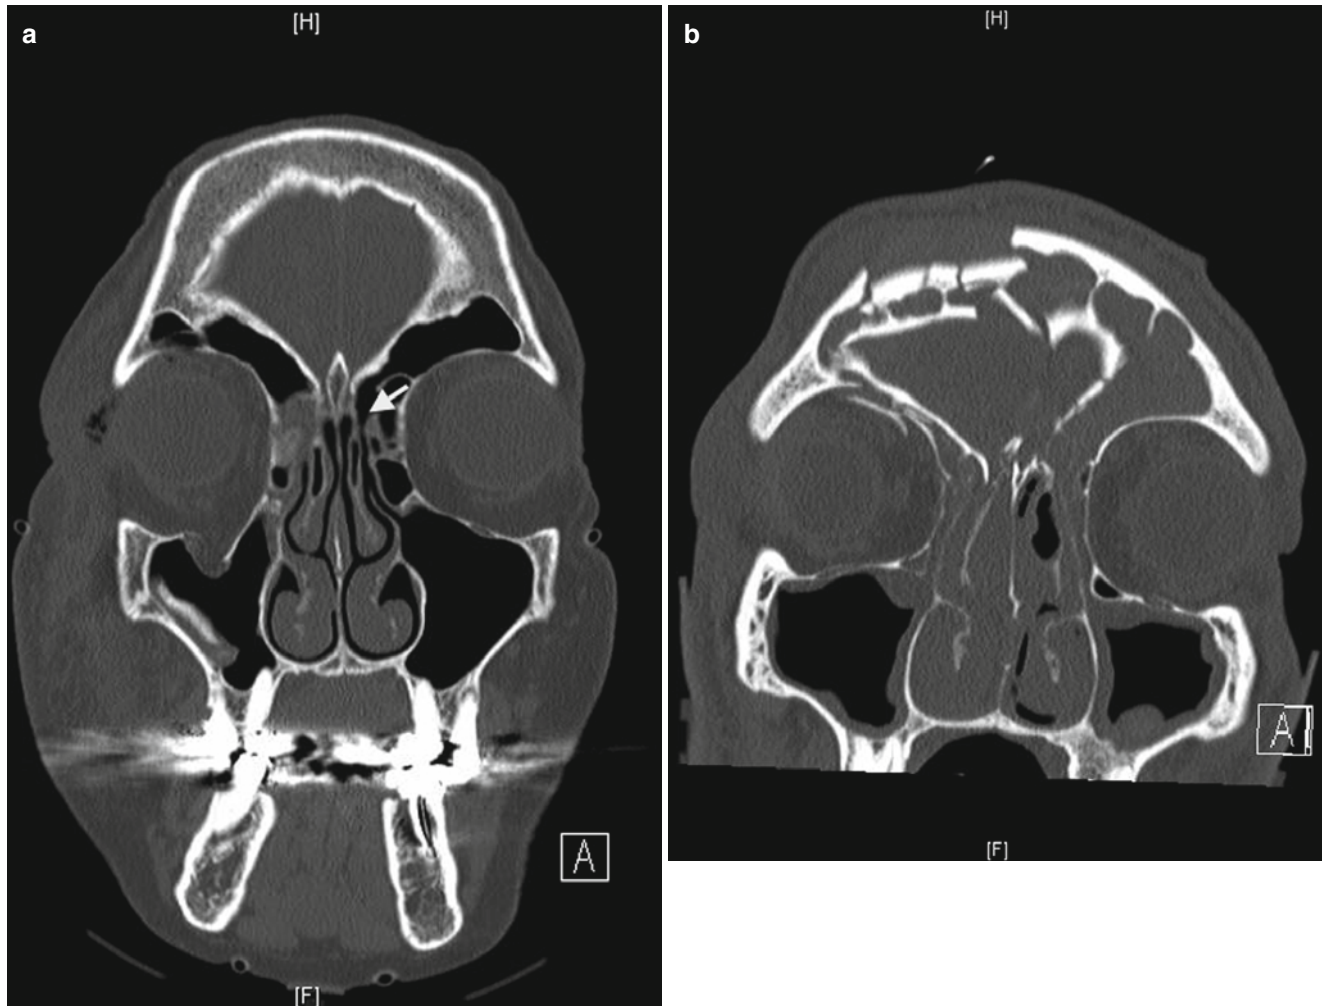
The frontonasal duct. (a) Coronal computed tomographic image of patent left frontonasal duct with “hourglass” appearance (*solid arrow*): a wide frontal infundibulum drains into a short, narrow ostium before expanding into the ethmoid infundibulum. Note incidental
